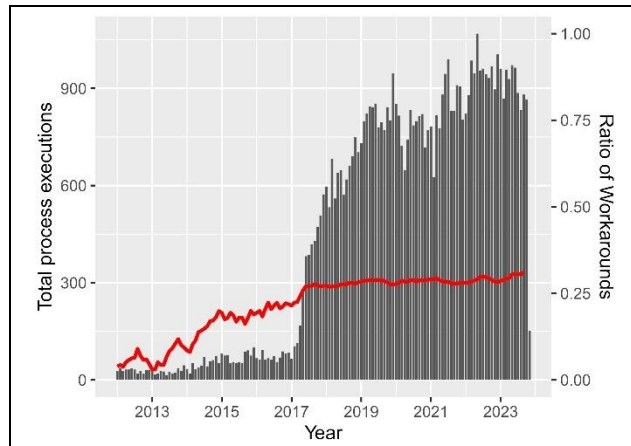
ER 7 – X-ray close to discharge. In the first part, the ratio of workarounds continuously grows from 10% to 30% but it stabilizes in 3-2017 when the process itself becomes more much more common.
